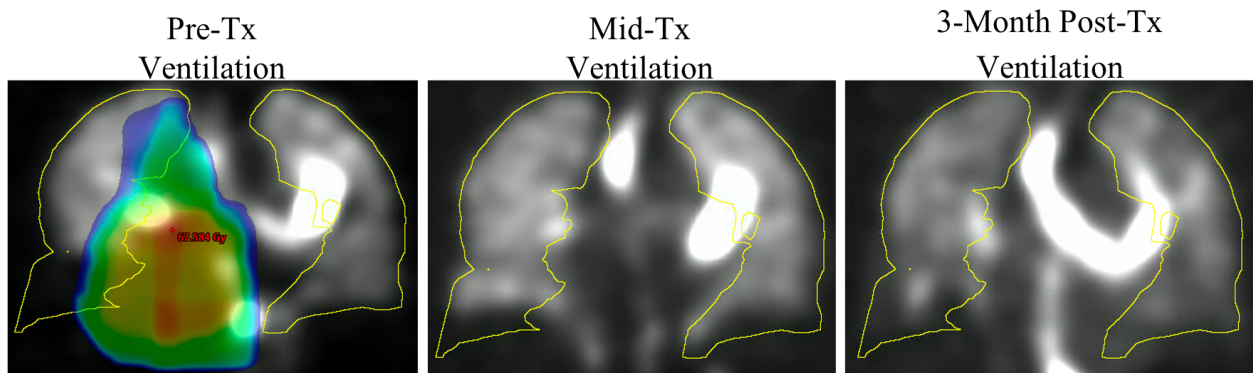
A qualitative example of the ventilation SPECT scans for patient UM025. Planned dose >30 Gy is overlaid on the pre-treatment ventilation scan.
